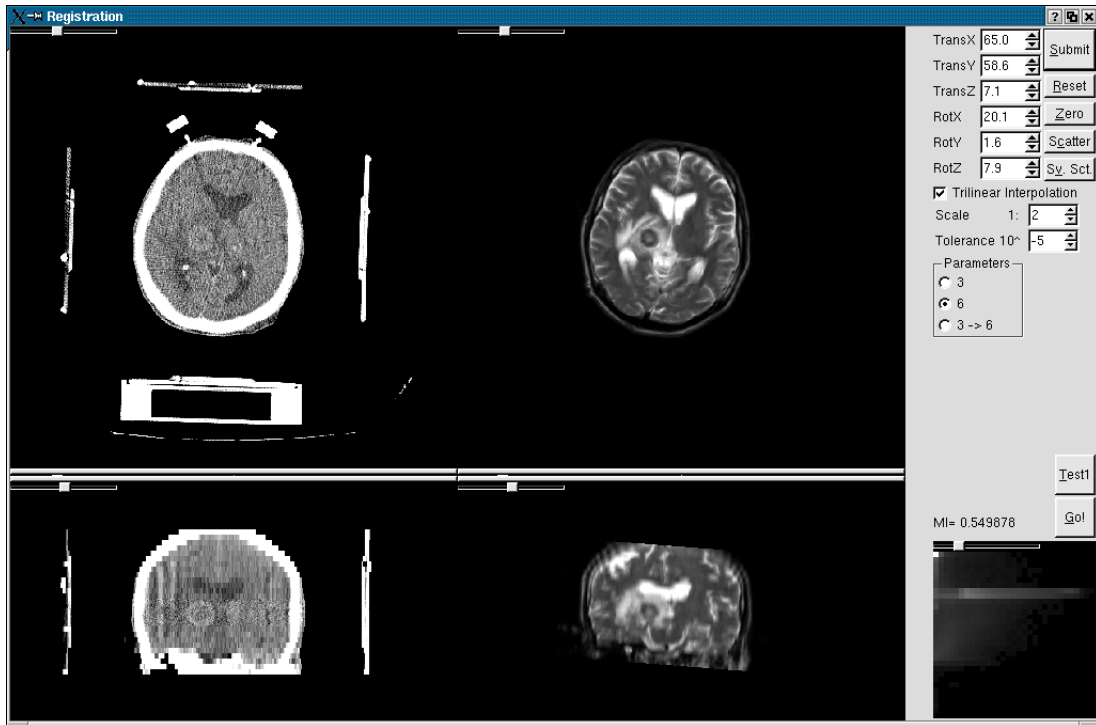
Screenshot of the CT – MRI fusion software
